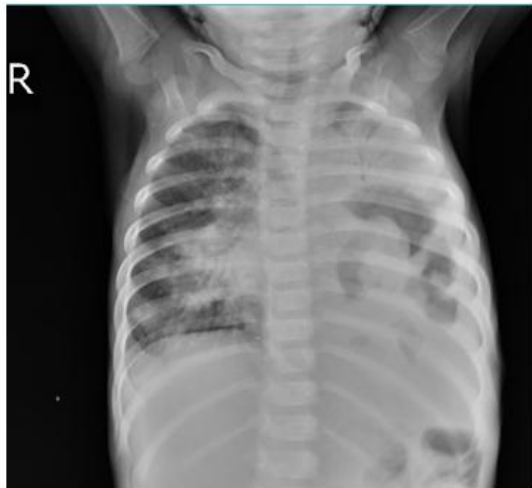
Chest X-Ray supine antero-posterior (AP) view was taken on admission, which revealed, left upper lobe collapse and consolidation patches with air bronchogram within and cavitary changes in left upper and mid zones with pneumonic changes in the right mid and bilateral lower zones.
